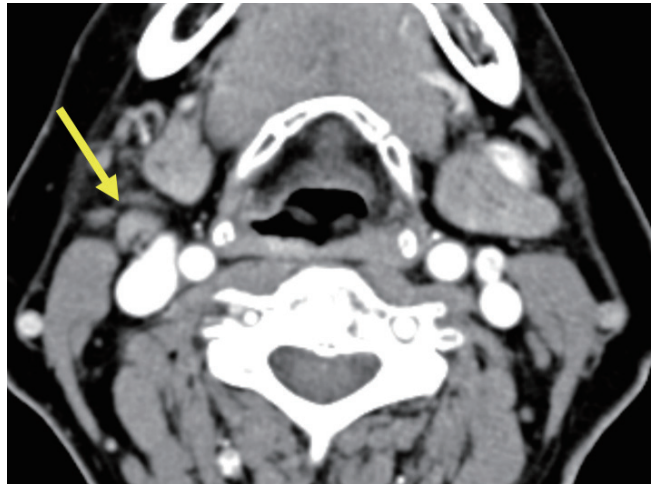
Axial computed tomography scan shows a lymph node with preserved hilar fat and hilar vessels but no internal cystic changes, heterogeneous enhancement, calcification, or strong enhancement (arrow). This lymph node would be classified into a probably benign category according to K-TIRADS. K-TIRADS = Korean Thyroid Imaging Reporting and Data System
